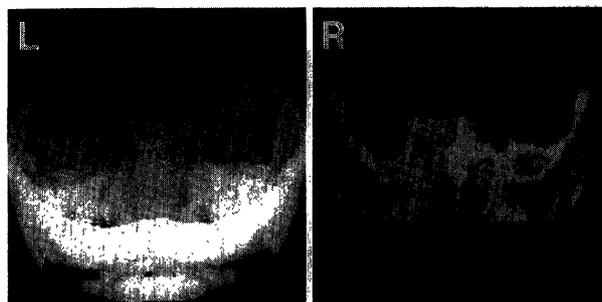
Postoperative 3D-CT scans showing adequate decompression of the optic nerve. Dysplastic bone still remains at the inferomedial aspect of the left optic canal and in the ethmoid sinus.
